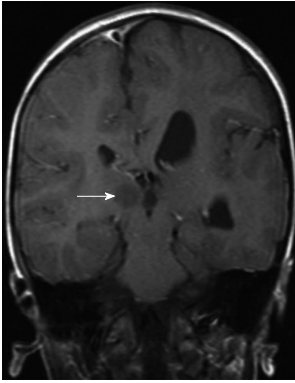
A 10-year-old boy with hemimegalencephaly. Coronal T1-weighted magnetic resonance image shows hypertrophy of the left cerebral hemisphere, mild enlargement of the left lateral ventricle, hamartoma (white arrow) in postero-medial area of the right thalamus.
